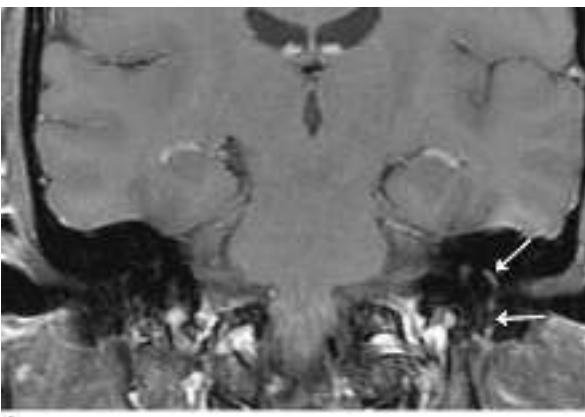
Axial and coronal T1-weighted images after gadolinium with fat suppression demonstrate diffuse smooth linear enhancement of the left facial nerve, involving the genu, tympanic, and mastoid segments within the temporal bone (arrows), without evidence of mass lesion. Although highly suggestive of Bell's palsy, similar findings may be seen with other etiologies such as Lyme disease, sarcoidosis, and perineural malignant spread.
